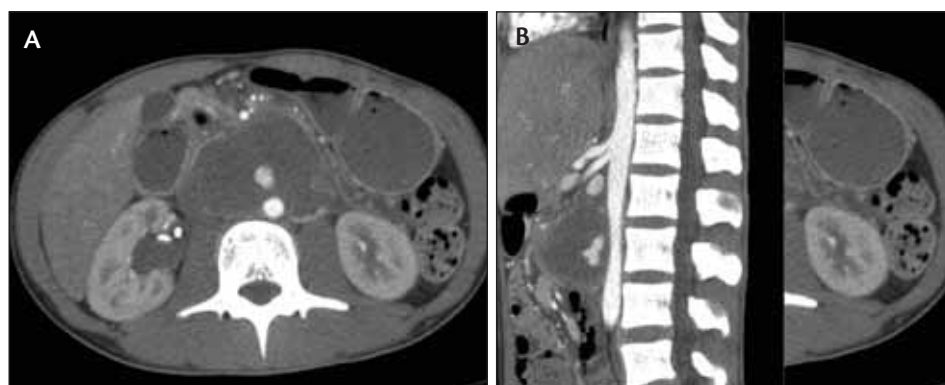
Axial slice (A) and sagittal slice (B) of a preoperative CT angiogram taken of the patient with aortic pseudoaneurysm secondary to choriocarcinoma. Contrast extravasation into the tumor mass from the aorta is demonstrated on arterial phase imaging.
